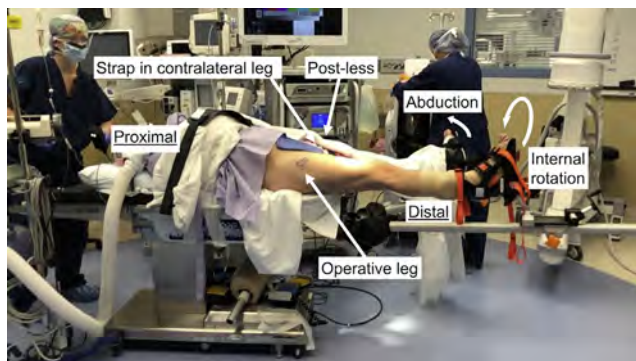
Patient positioning before Trendelenburg. The post has been removed and the strap has been positioned on the contralateral leg. The operative leg is internally rotated so that the patella is parallel with the floor. The nonoperative leg is abducted enough for radiographs to have adequate space.
